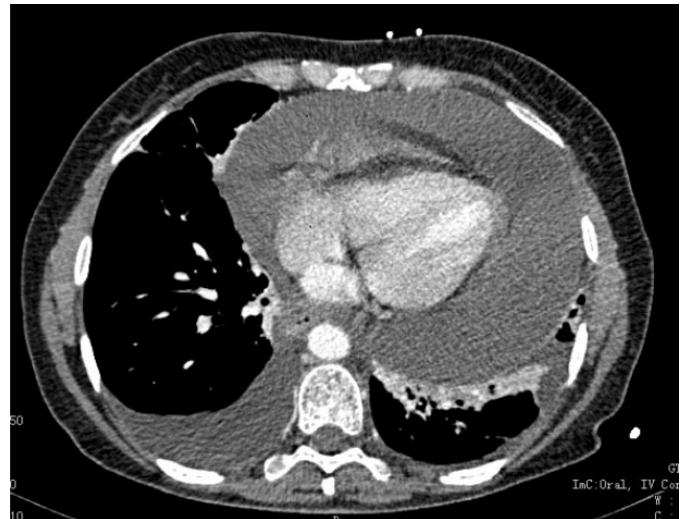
CT chest showing massive circumferential pericardial effusion.
